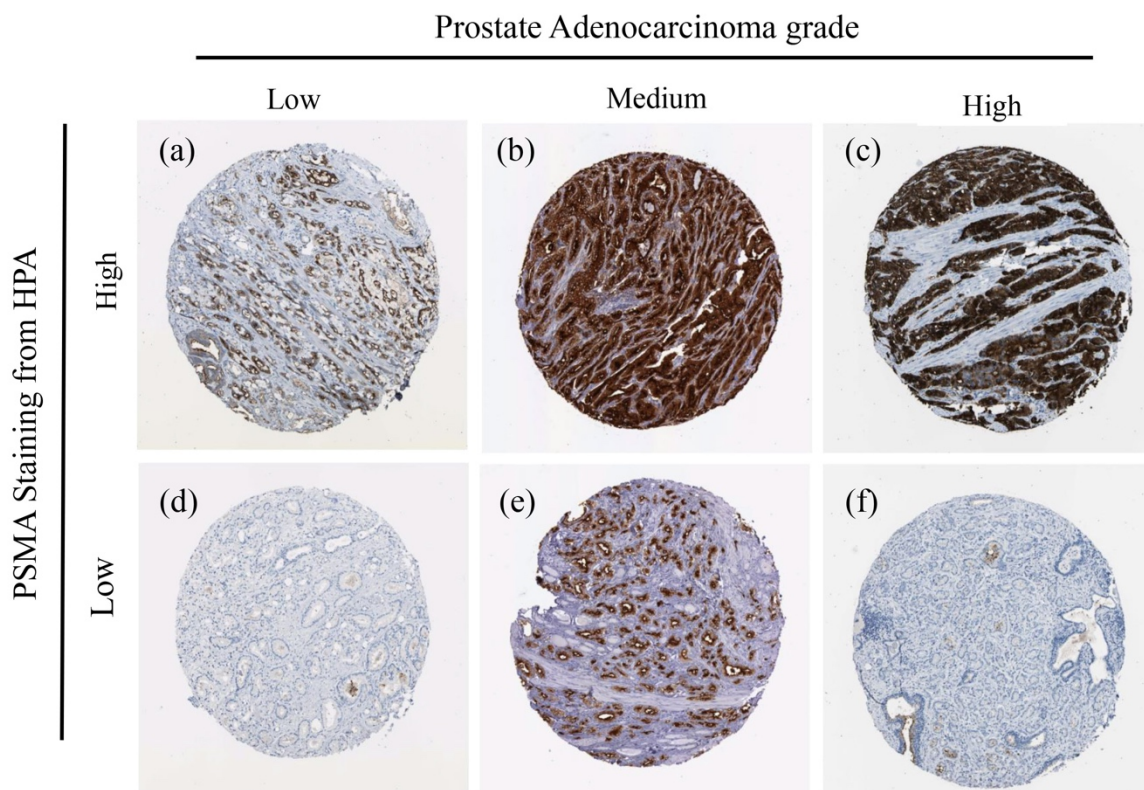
The evaluation of PSMA levels.
